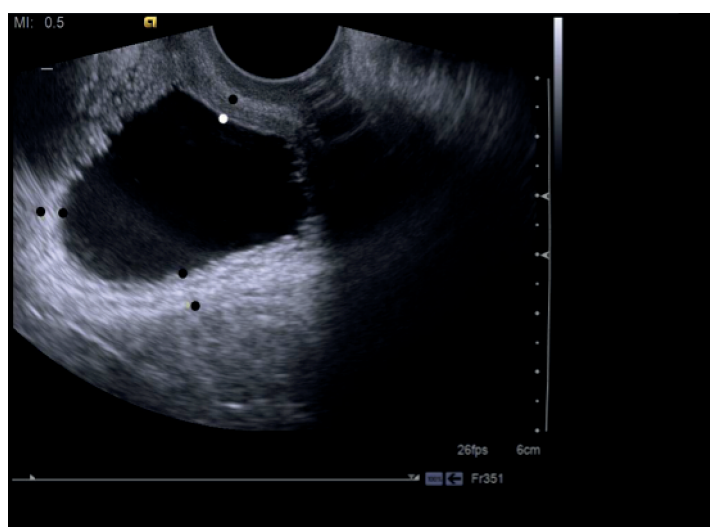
Transvaginal ultrasound in coronal section to measure the axial dimension of the bladder.
